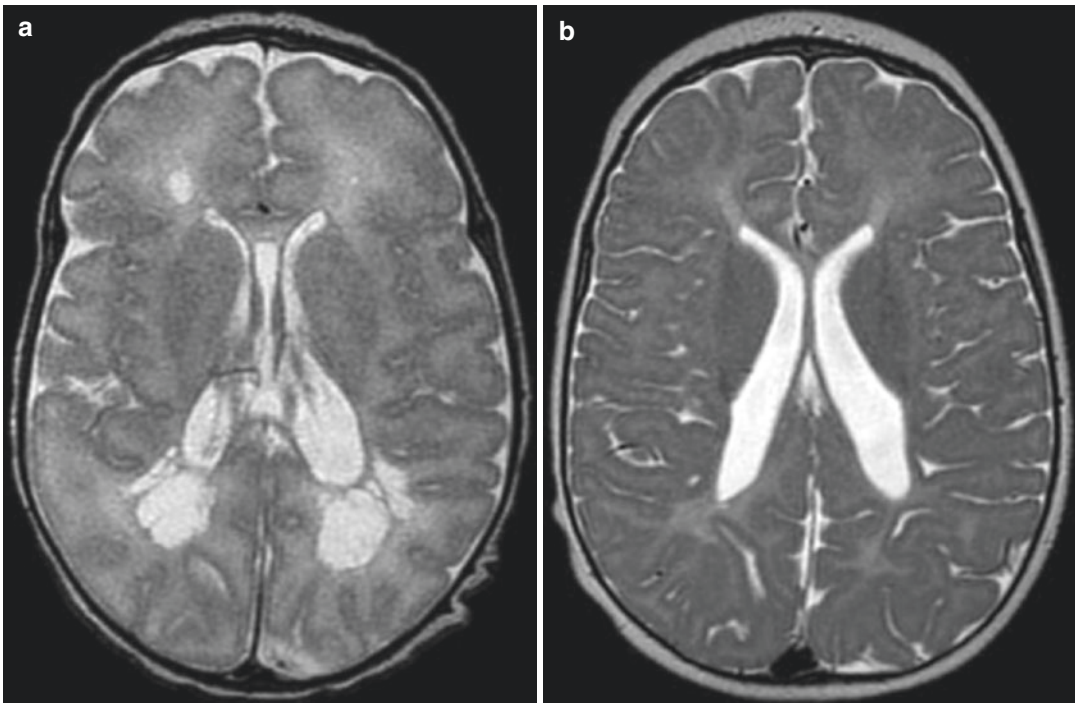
(a) Axial T2-weighted image shows multiple foci of cystic periventricular leukomalacia in a 6-week-old infant. (b) Six months later, the cystic areas are no
